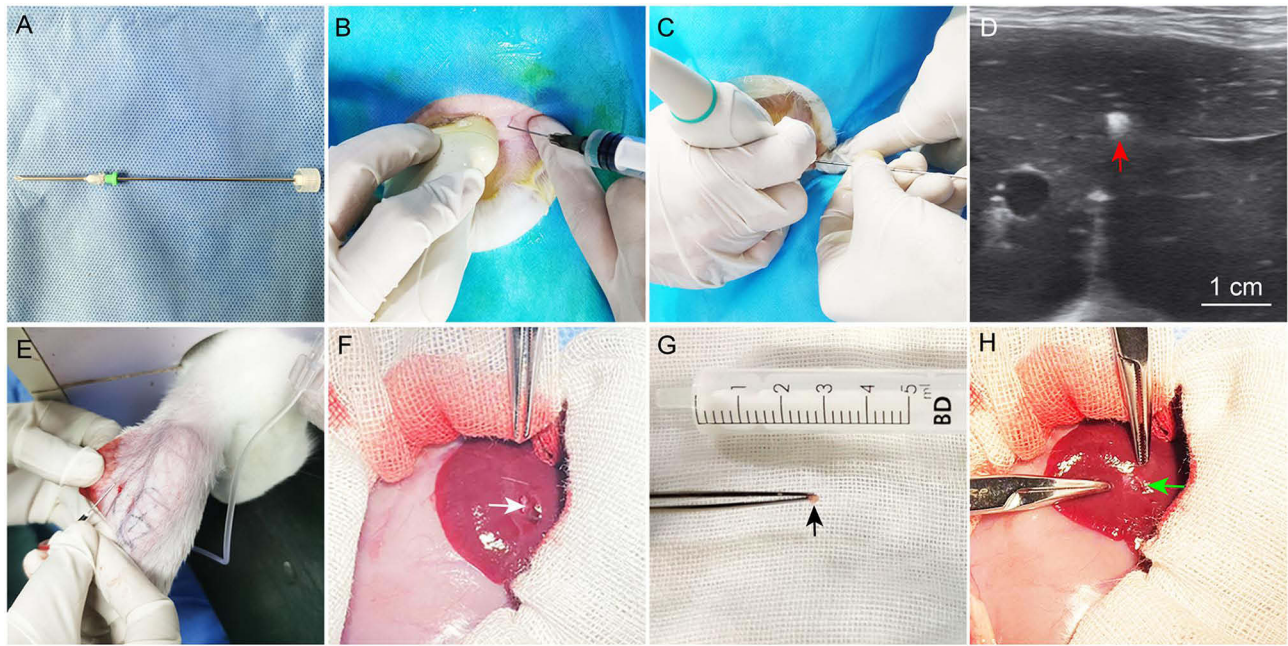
Implantation of VX2 tumor tissue fragments. (A) The VX2 tumor implantation kit comprises a smooth, flat-tipped pusher with a removable piston and a 16-gauge needle. (B) Ultrasound examination confirming the hepatic implantation site, followed by local infiltration anesthesia at the designated puncture point on the body surface. (C and D) Under ultrasound guidance, fresh VX2 tumor tissue fragments, along with gelatin sponge, are implanted into the liver parenchyma. Post-implantation ultrasound shows a hyperechoic gelatin sponge mass within the parenchyma (red arrow). (E) General anesthesia was induced by intravenous injection of 3% pentobarbital sodium (30 mg/kg) via the marginal ear vein. (F) After laparotomy, the liver is adequately exposed, and an implantation incision approximately 5 mm in depth is created in the parenchyma (white arrow). (G and H) Fresh VX2 tissue fragments (black arrows) are embedded into the hepatic incision and sealed with an appropriate amount of hemostatic sponge (green arrows) to achieve hemostasis.
